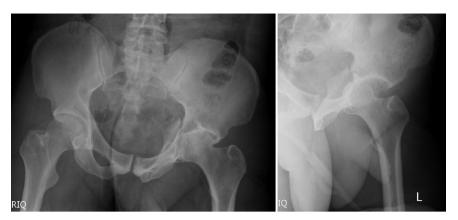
Anteroposterior radiograph of the pelvis with left hip fracture-dislocation. Chip fragment of the posterior wall of the acetabulum and dislocation of the femoral head from the acetabular socket are evident.
